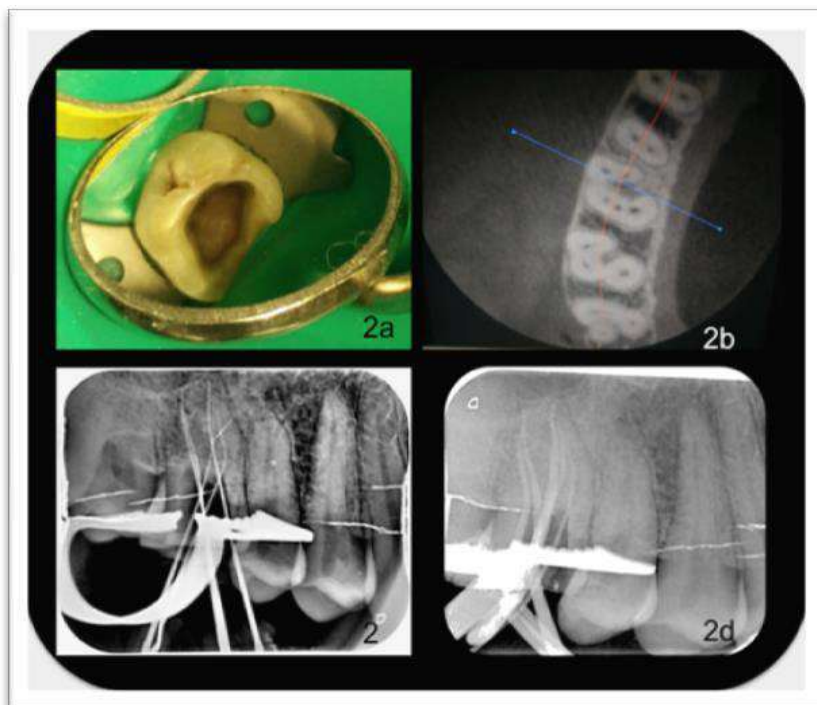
2a. Clinical image showing 5 canal orifices, 2b. CBCT image, 2c. Working length determination, 2d. Master cone selection and obturation
